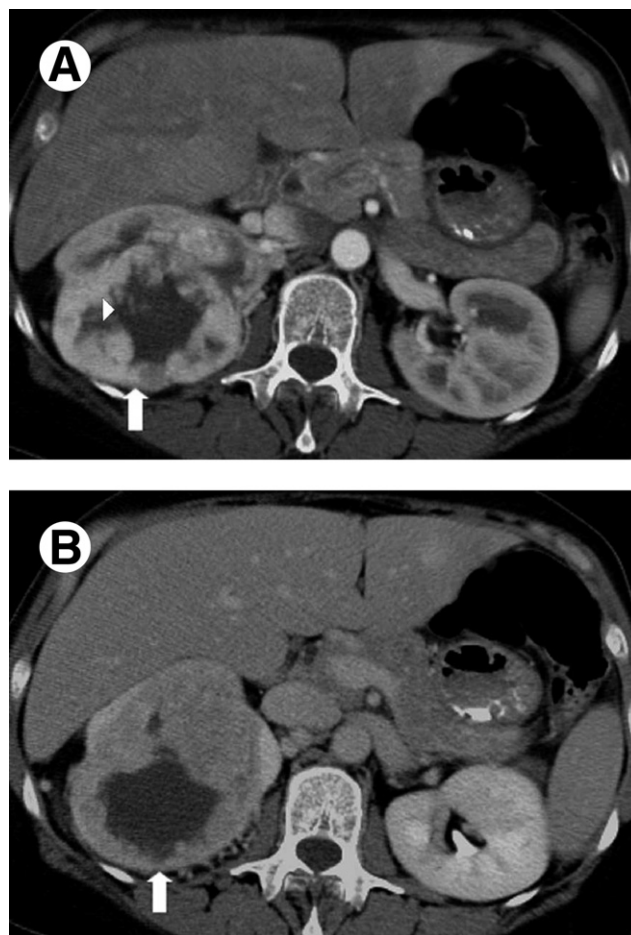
Sporadic clear cell RCC. Axial CT images obtained during the corticomedullary (A) and nephrographic (B) phase shows a large, heterogeneously enhancing right renal mass (arrow) with irregular central area of necrosis (arrowhead). Note that the lesion enhances intensely on the corticomedullary phase and shows prompt de-enhancement on the nephrographic phase.
